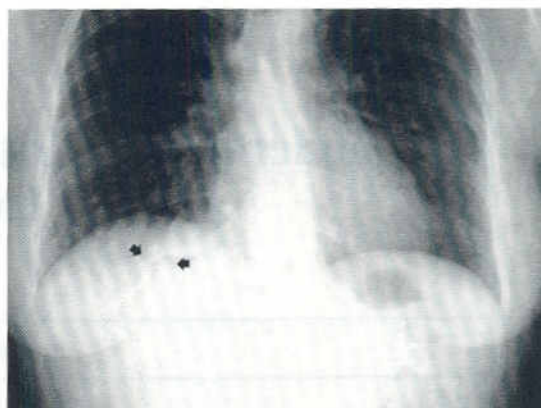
Chest X-ray. Parenchymal thickening in the right posteromedial pulmonary basis.
